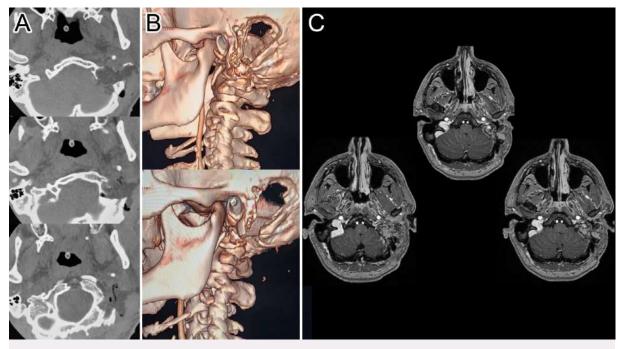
Postoperative CT scans (A) and MRI studies (C). Axial images display complete bone removal of the cystic erosive occipital lesion, which has invaded the left jugular foramen. A three-dimensional bone reconstruction (B) demonstrates the lateral craniocervical junction bone resection.
